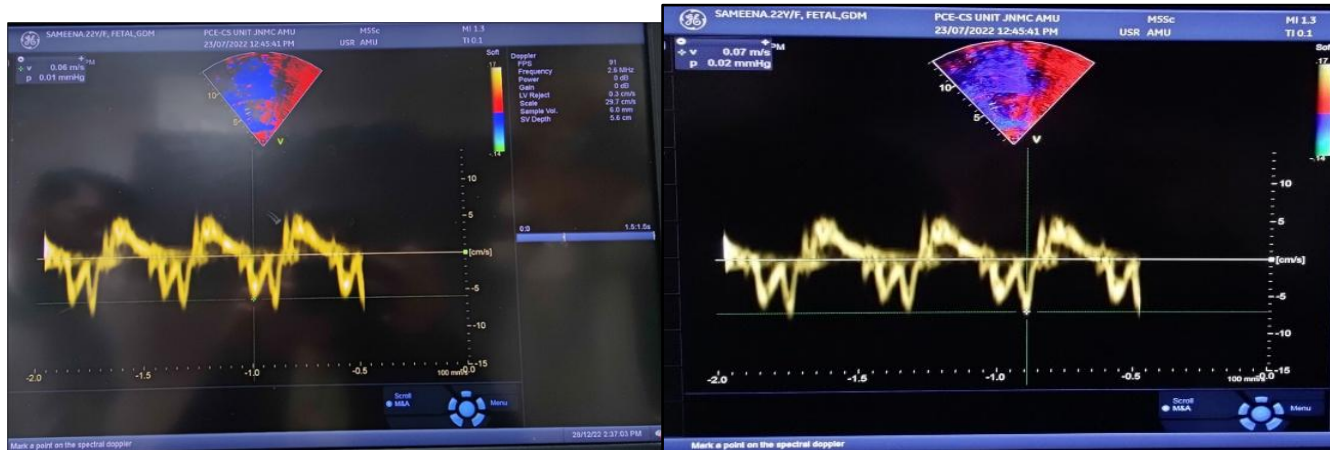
Tissue Wave doppler imaging Ea and Aa velocity
